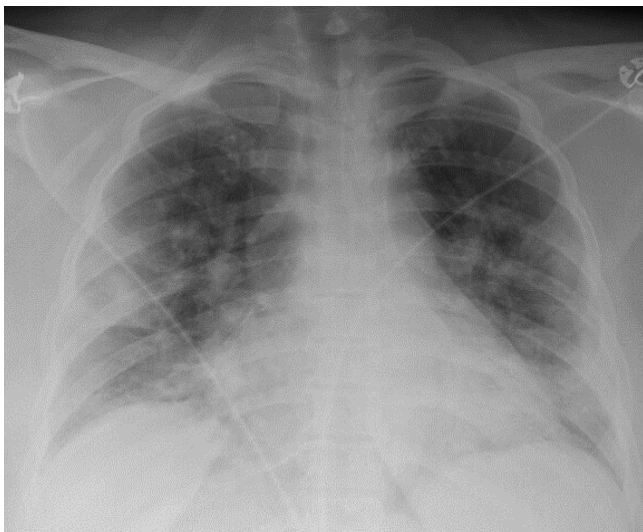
Chest X-ray on admission showing bilateral airspace opacities
